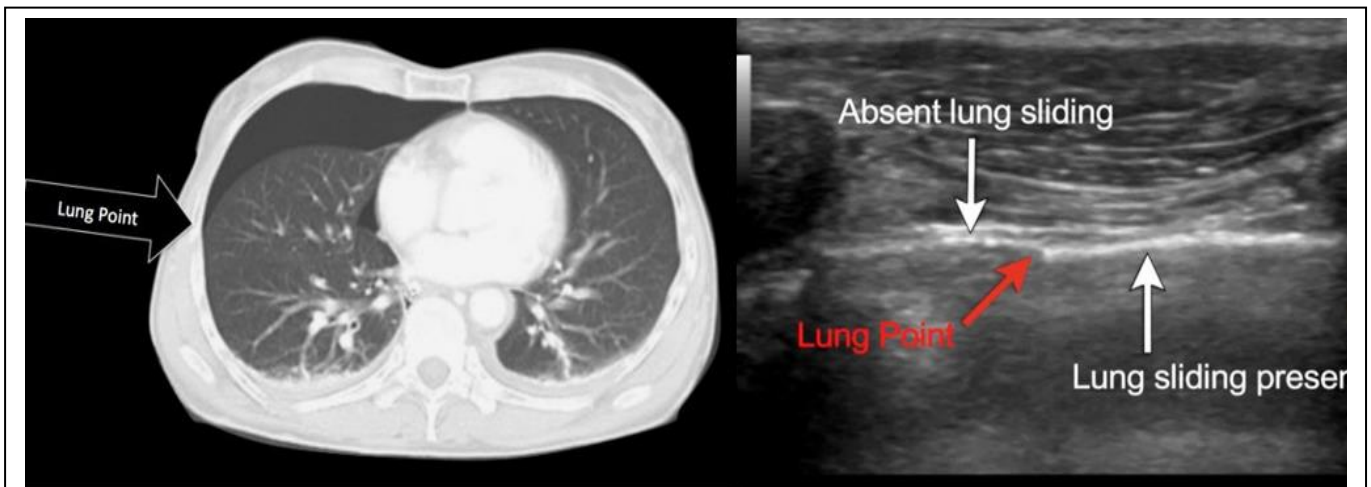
CT image showing position of lung point on the left-hand side
